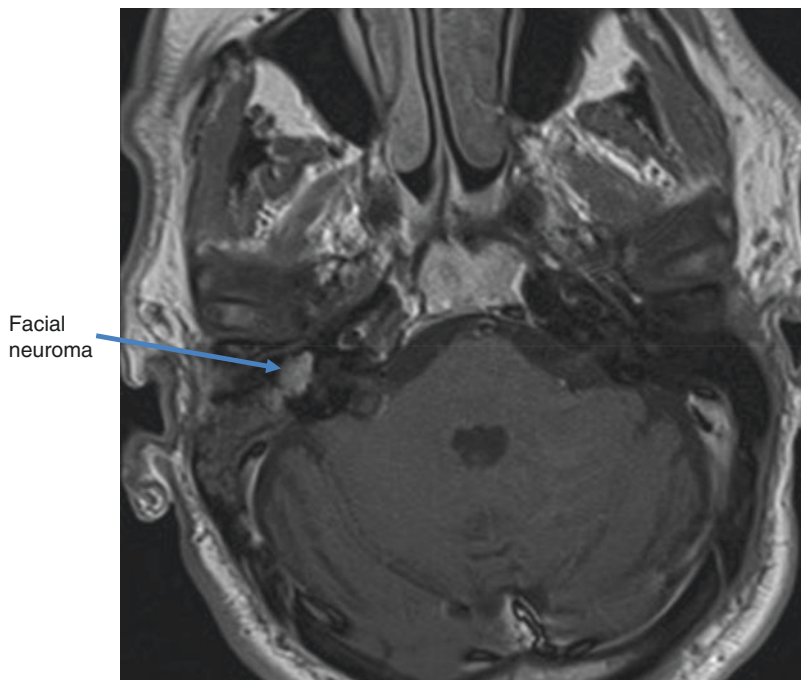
MRI IAM contrast-enhanced T1 weighted axial image demonstrates enhancement of the labyrinthine facial nerve on the right side in the region of the geniculate ganglion, with ‘tuft’ of perineural enhancement at IAM fundus
